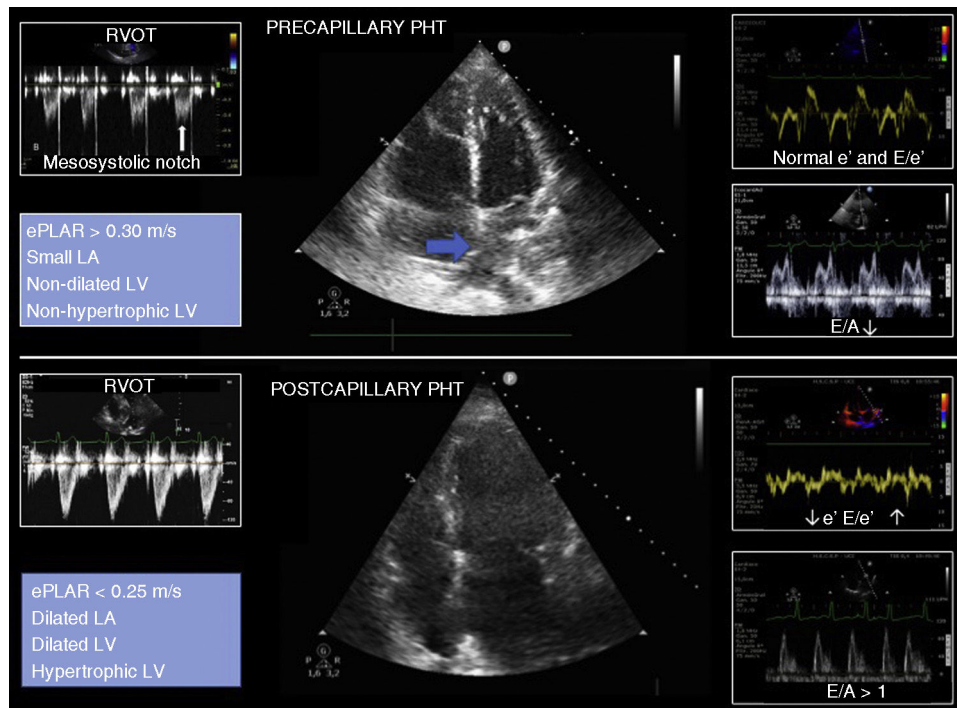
Echocardiographic signs suggestive of pre- and postcapillary pulmonary hypertension. The blue arrow indicates the interatrial septum bulging towards the left atrium. LA: left atrium; ePLAR: echographic pulmonary to left atrial ratio = $[V_{\max}TI]/(E/e')$ mitral]; PHT: pulmonary hypertension; RVOT: right ventricle outflow tract; LV: left ventricle.
